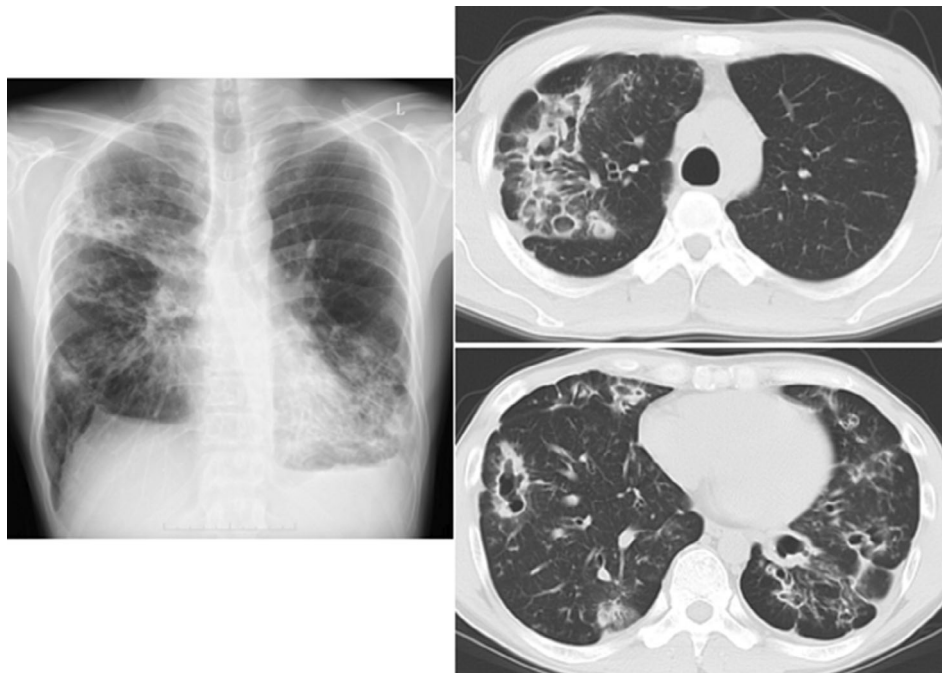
Chest radiograph and computed tomography. Prominent bronchiectasis was observed predominantly in the right upper lobe and both lower lobes of the lungs. Some cases of bronchiectasis exhibit cystic dilatation and contain mucous plugs.
